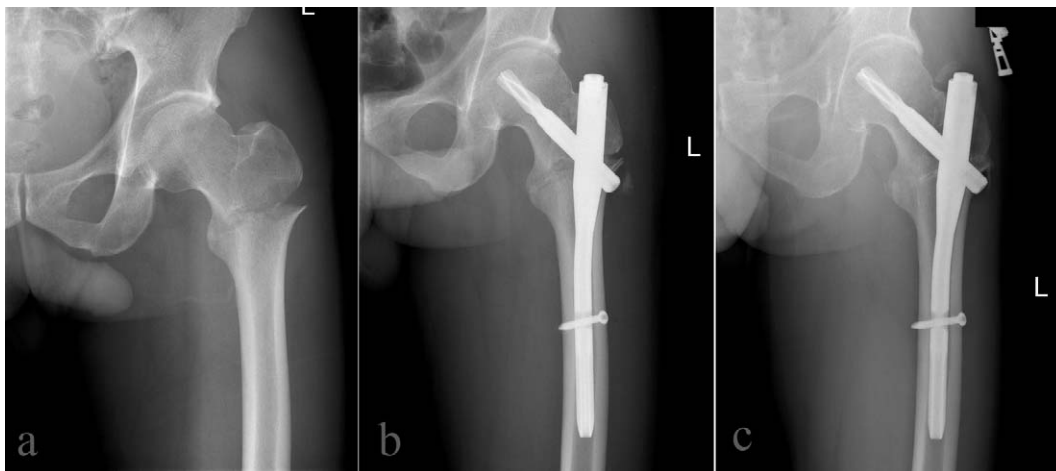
A 76-year-old man sustained a pertrochanteric fracture of left hip when she fell outside home (a). The fracture was reduced and fixed with a PFNA (b), and X-ray 12 months after the operation (c) while living at home and walking independently. .
